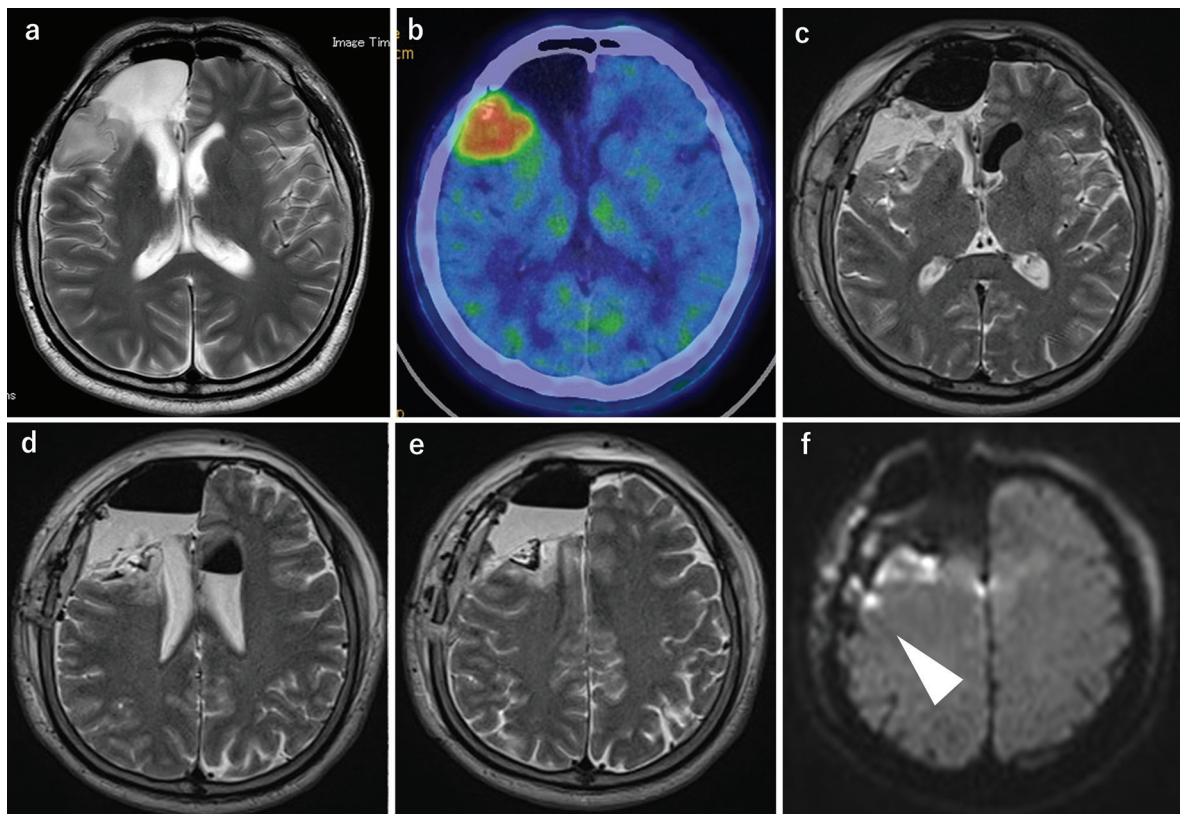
Perioperative neuroimaging. A T₂-weighted magnetic resonance imaging (MRI) (a) and ¹¹C-methionine positron emission tomography (b) indicating the recurrence of the tumor next to the previous surgical cavity in the right frontal lobe. T₂-weighted MRI on the day after surgery showing the postoperative cavity after recurrent tumor resection with open anterior horn of the right lateral ventricle (c). BCNU wafers placed on the surface of the cavity after closing the lateral ventricle with an absorbable compressed gelatin sponge (d and e). The diffusion-weighted MRI shows a small high intensity spot-like area in the right frontal lobe (f, white arrow head), the small cerebral ischemia area located apart from the surgical cavity.
